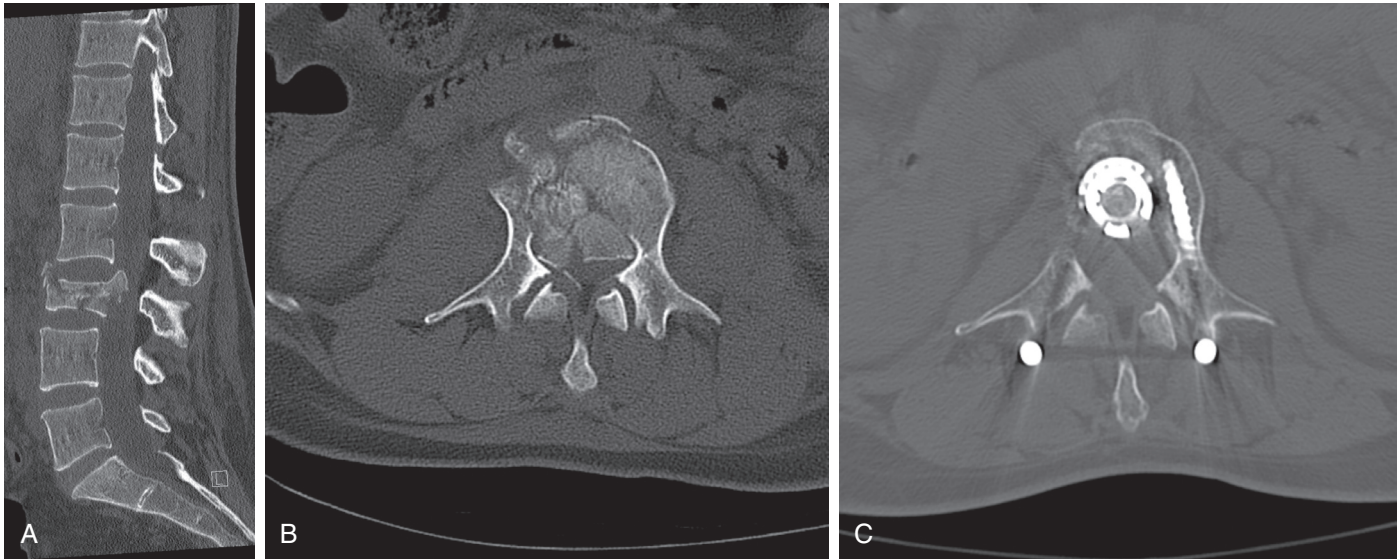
■ A, Sagittal CT demonstrates an L3 burst fracture that presented with cauda equina syndrome. B, Axial CT demonstrates severe compression of the spinal canal. C, The canal was decompressed surgically with a minimally invasive approach resulting in significant root recovery.
